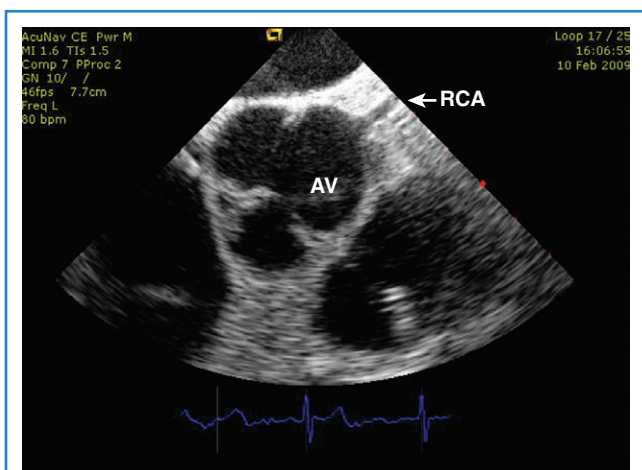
Intracardiac echocardiography image of the aortic valve (AV) in cross-sectional view. Note the right coronary artery (RCA) arising from the right coronary cusp.
